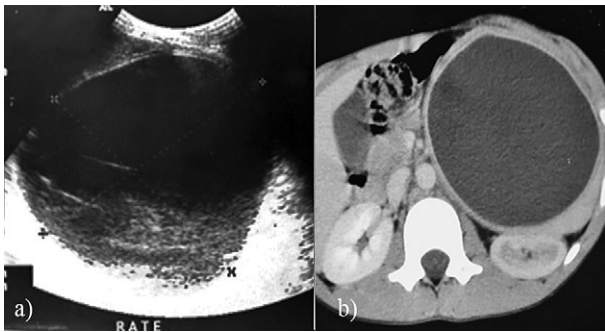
Splenic hydatid cyst. A 12-year-old girl presents with a painful mass in the left hypochondrium: a) oblique ultrasound scan; b) axial contrast CT image; A large fluid collection, rounded, with well-defined borders and hydatid sand are well seen by US (type I Gharbi's classification) within the spleen.
